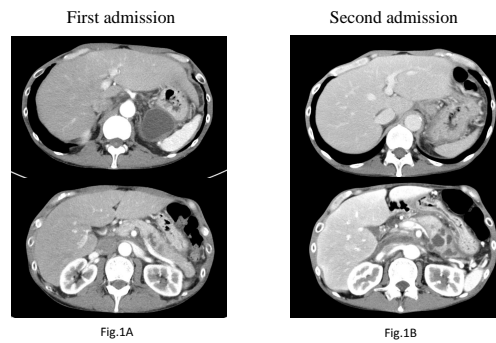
(A) Abdominopelvic computed tomography (CT) scan. CT image shows a cystic lesion 45 mm in diameter localized in the pancreatic tail and several low-density areas in the pancreatic body. (B) Pancreatic pseudocyst suspected of perforating.
